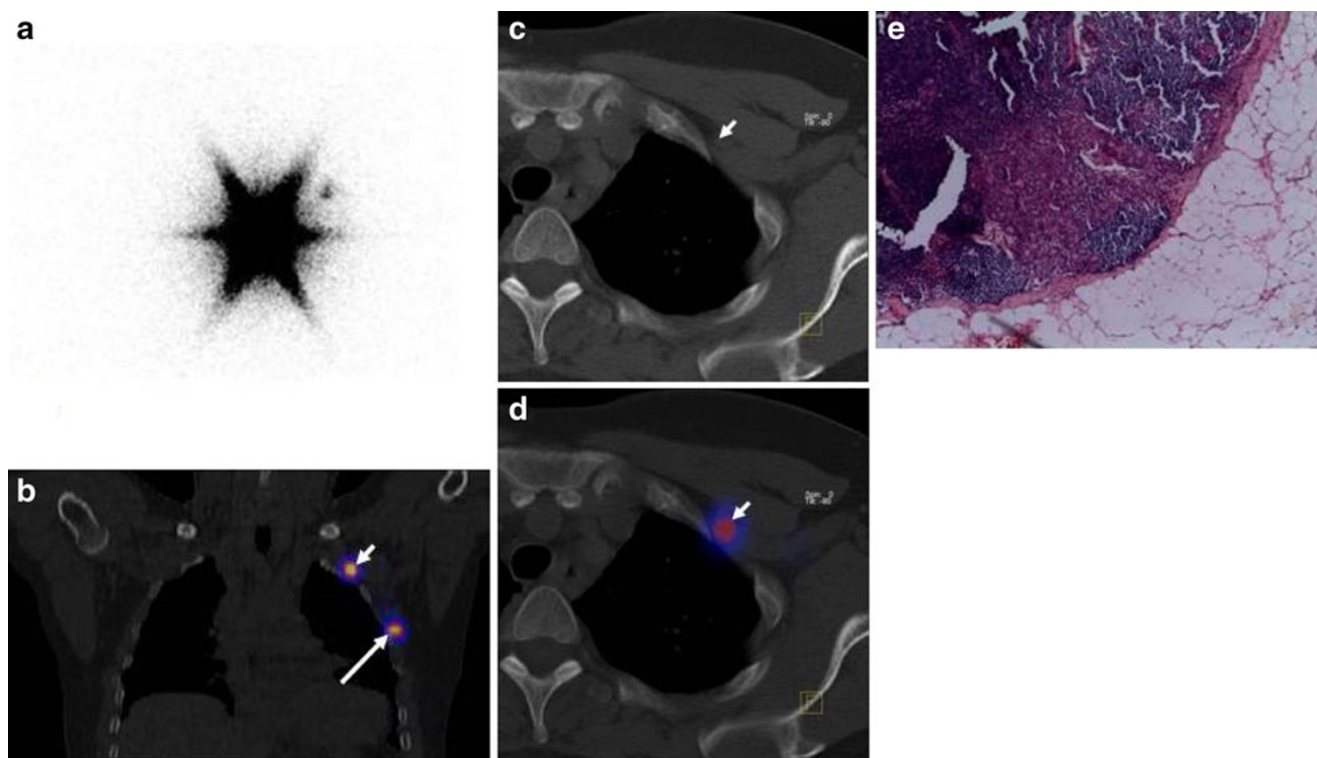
SPECT/CT case acquired on Symbia T2 (Siemens Healthcare). A 54-year-old woman with breast carcinoma (pT1) for SLN mapping. Planar scintigraphy (a) detected sentinel lymph node (SLN). Subsequent SPECT/CT shows two SLNs: one in (b) typical localisation and (c, d) one in the upper axilla with 7-mm diameter.
